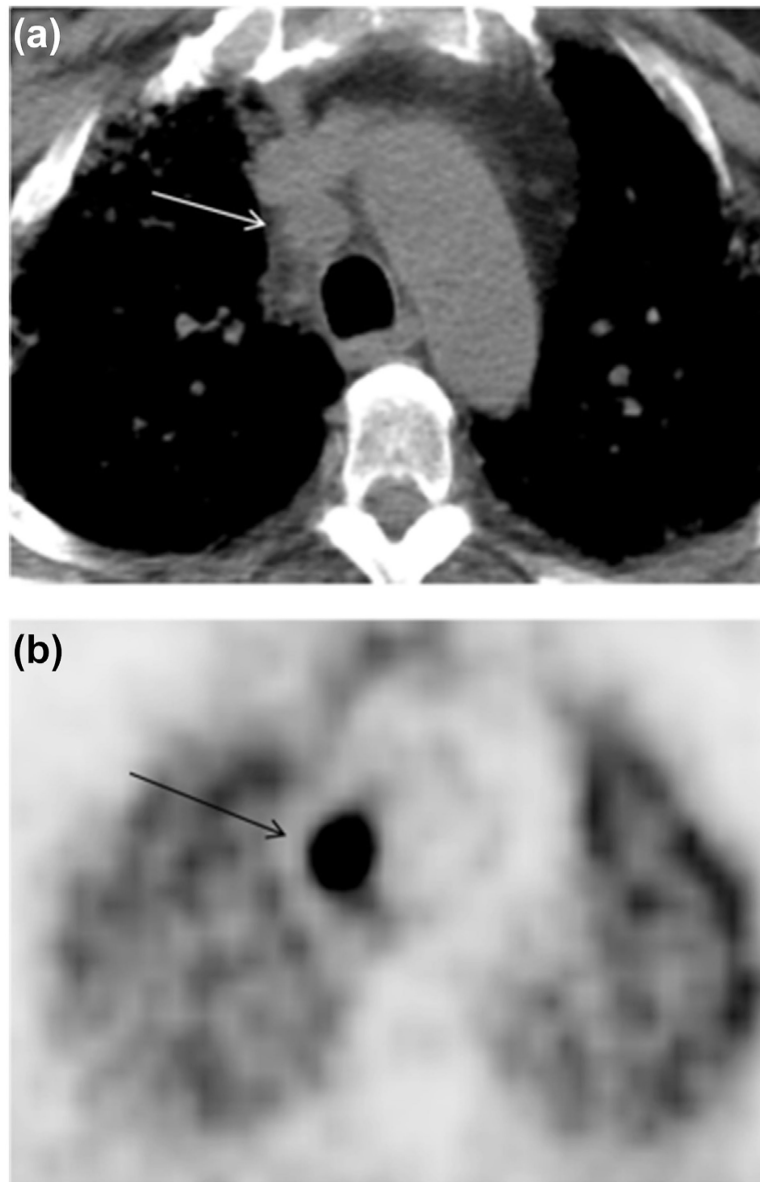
Axial CT image (a) revealed a rounded lymph node on 4R (arrow). Long-axis diameter is 1.86 cm, and short-axis diameter is 1.63 cm. The axial S/L ratio is 0.88. The lymph node has un-sharpness of border. The PET image (b) revealed high FDG uptake (arrow) of lymph node. The pathology result is squamous cell carcinoma.
